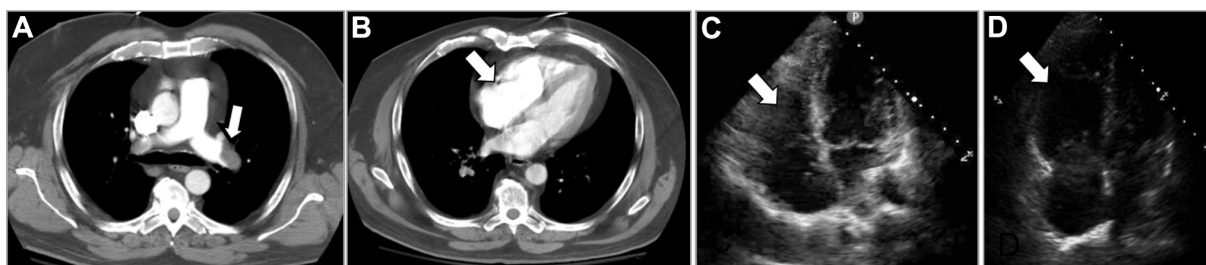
A, Contrast-enhanced CT of the chest showing filling defects within the pulmonary arteries. The arrow points to thrombi within the left main pulmonary artery. B, CT image of the heart and a dilated right ventricle (arrow) with a diameter greater than that of the left ventricle. C, Apical 4-chamber-view cardiac ultrasonographic view showing normal right ventricle shape and dimension (arrow). D, Cardiac ultrasonographic apical 4-chamber view of the severely dilated right ventricle (arrow).
